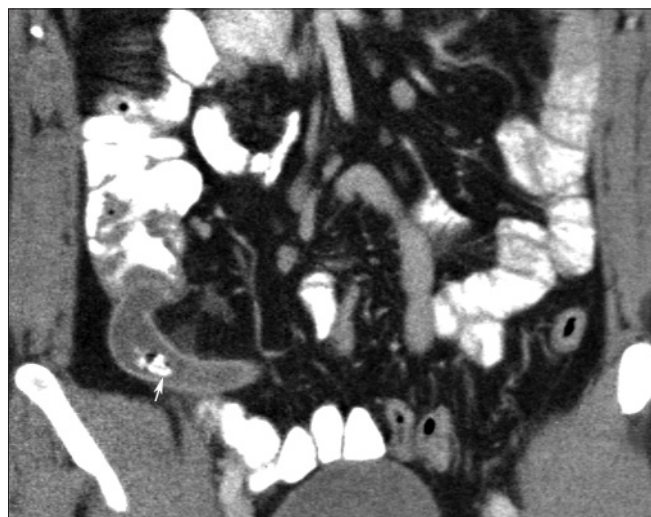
Contrast-enhanced (intravenous and positive oral) coronal multiplanar reconstruction CT image shows an inflamed AM containing appendicoliths (arrow) in an AA case
